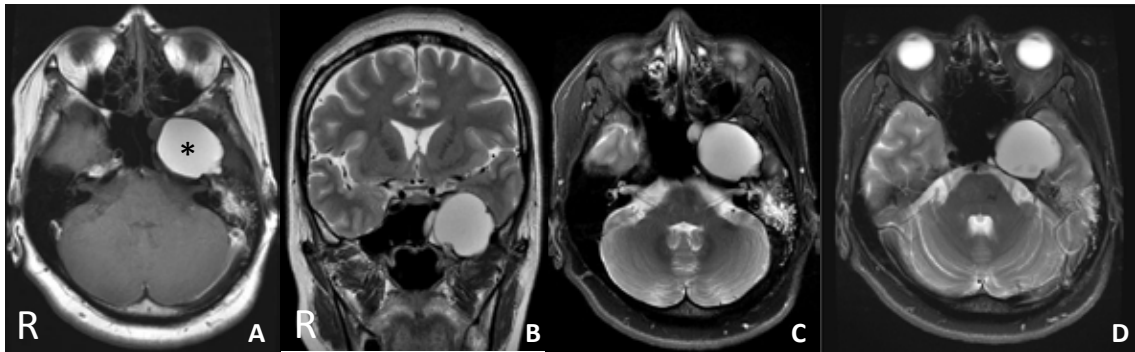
Magnetic resonance images showed a large cystic lesion (*) in the left petrous apex with high signal intensity on T1 (A)- and T2 (B)-weighted images and also on fat suppression T2 (C)-weighted images. Three-dimensional fast imaging employing steady-state acquisition MR imaging (D) showed ICA located medial to the lesion and trigeminal nerve was not identified along the medial wall of the cyst.
